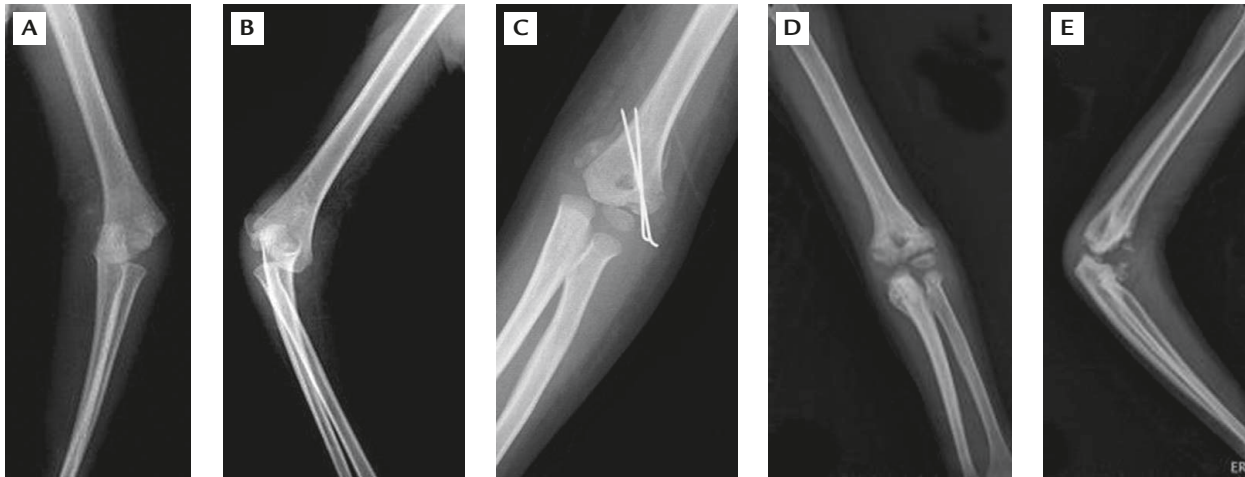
Case 2: (A, B) preoperative X-rays; (C) X-ray 4 weeks after operation; (D, E) X-rays at 28 months' follow-up showed poor reduction of the lateral condyle with malunion, and heterotopic calcification around the elbow joint.
